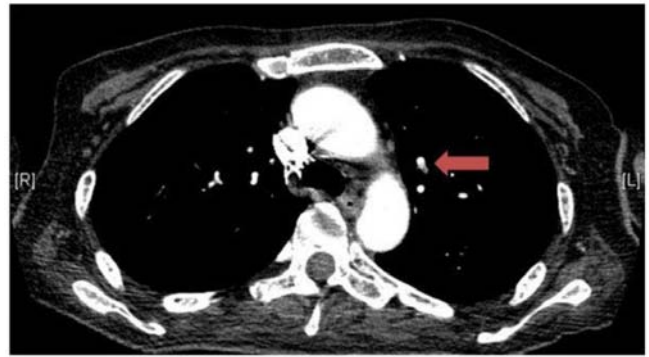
Thoracic computed tomography scan of the patient demonstrating a pulmonary microembolism (red arrow).
